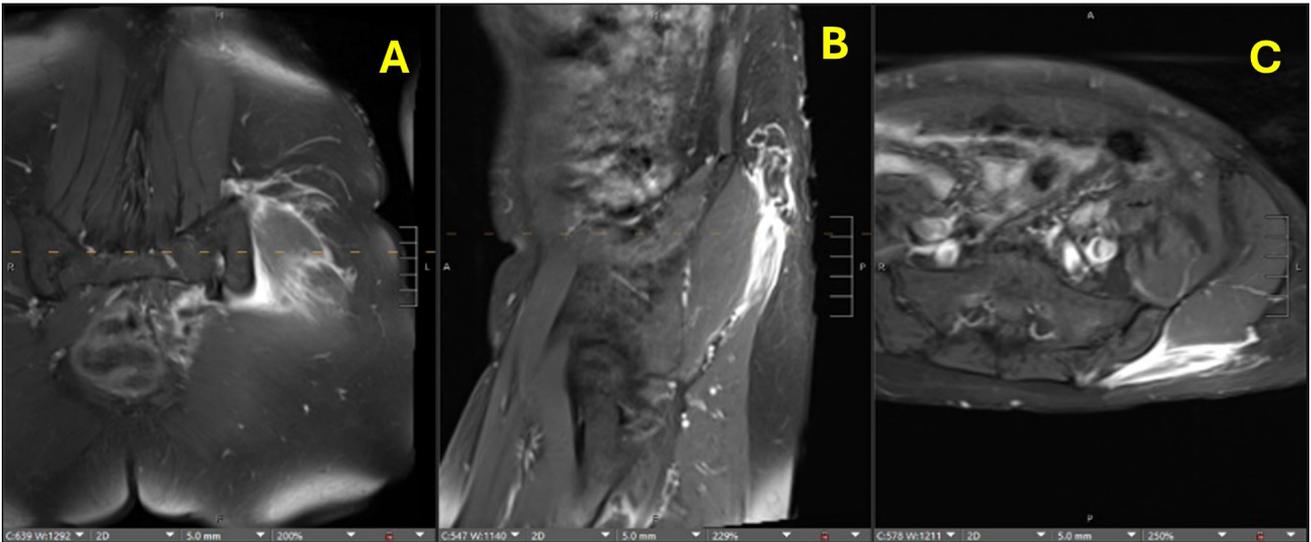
Pelvic magnetic resonance imaging. (A) Axial T1-weighted with contrast demonstrating hyperintense left gluteal diffuse neurofibroma. (B). Parasagittal T1-weighted with contrast that shows hyperintense posterior subcutaneous diffuse neurofibroma (C). Axial T1-weighted with contrast that demonstrates hyperintense posterior subcutaneous diffuse neurofibroma.
